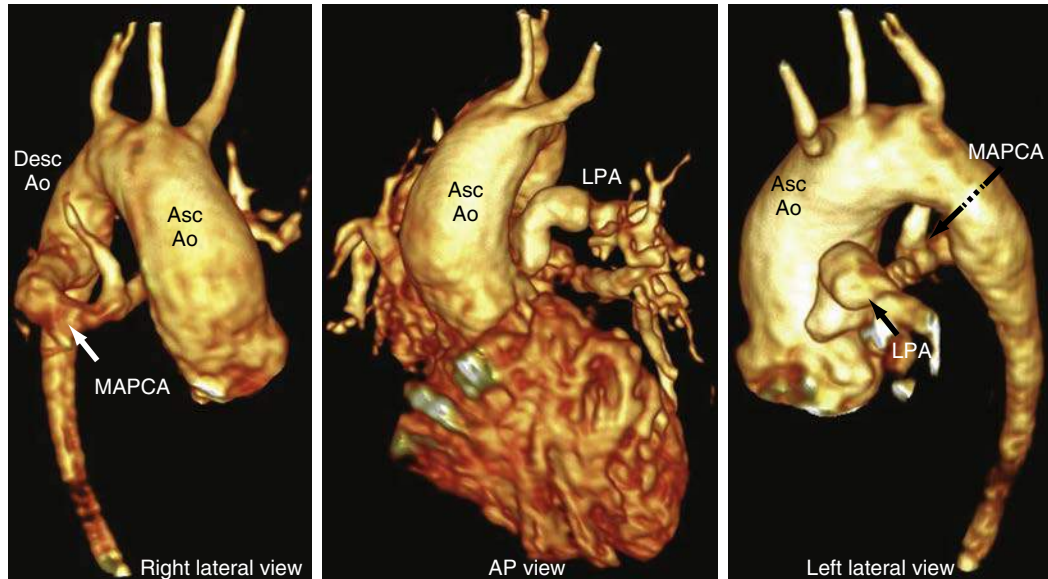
Maximum intensity projection reconstruction of a magnetic resonance imaging angiogram in a patient with pulmonary atresia with ventricular septal defect (VSD), shown in three different views. From the right, a large collateral MAPCA from the descending aorta is visible to the right pulmonary artery, which courses underneath the aortic arch and is confluent to the LPA, shown from the left. The center shows an anteroposterior (AP) projection, wherein the absence of a large main pulmonary artery (MPA) can be appreciated. Ao, Aorta; LPA, left pulmonary artery; MAPCA, major aortopulmonary collateral artery.
